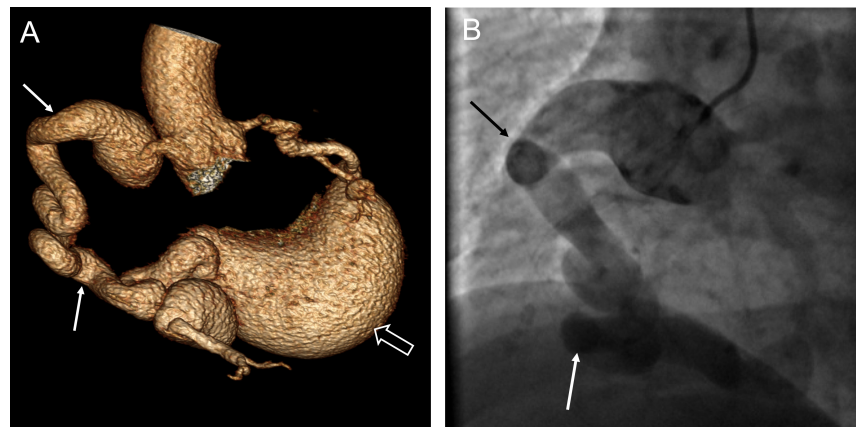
A 58-year-old woman with known RCA to the coronary sinus fistula referred for preoperative evaluation. (A) Volume rendered image of coronary computed tomographic angiography (CCTA) and (B) conventional angiography image demonstrate dilated and tortuous RCA (arrows) draining into the aneurysmal coronary sinus (open arrow).
